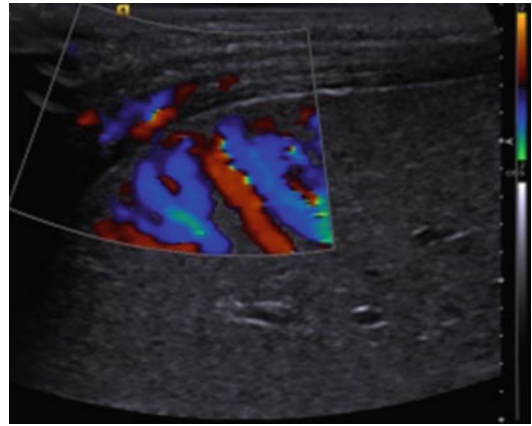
Sonographic scan shows the increment of subcapsular flow in BA. It is a consequence of dilatation and hypertrophy of hepatic vessels in the subcapsular area, secondary to portal hypertension
